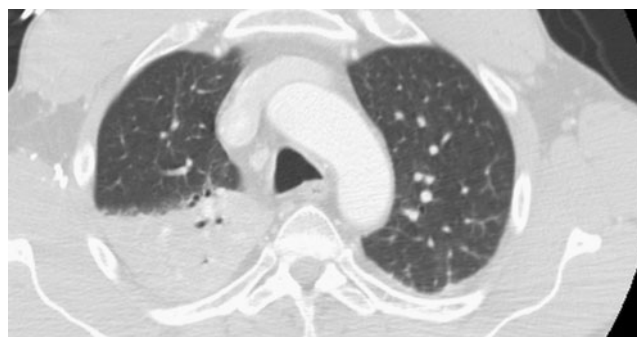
A 48-year-old man with novel influenza A (H1N1), HIV, and Burkitt's lymphoma. CT demonstrates focal non-segmental right upper lobe consolidation. This was the only significant abnormality detected
